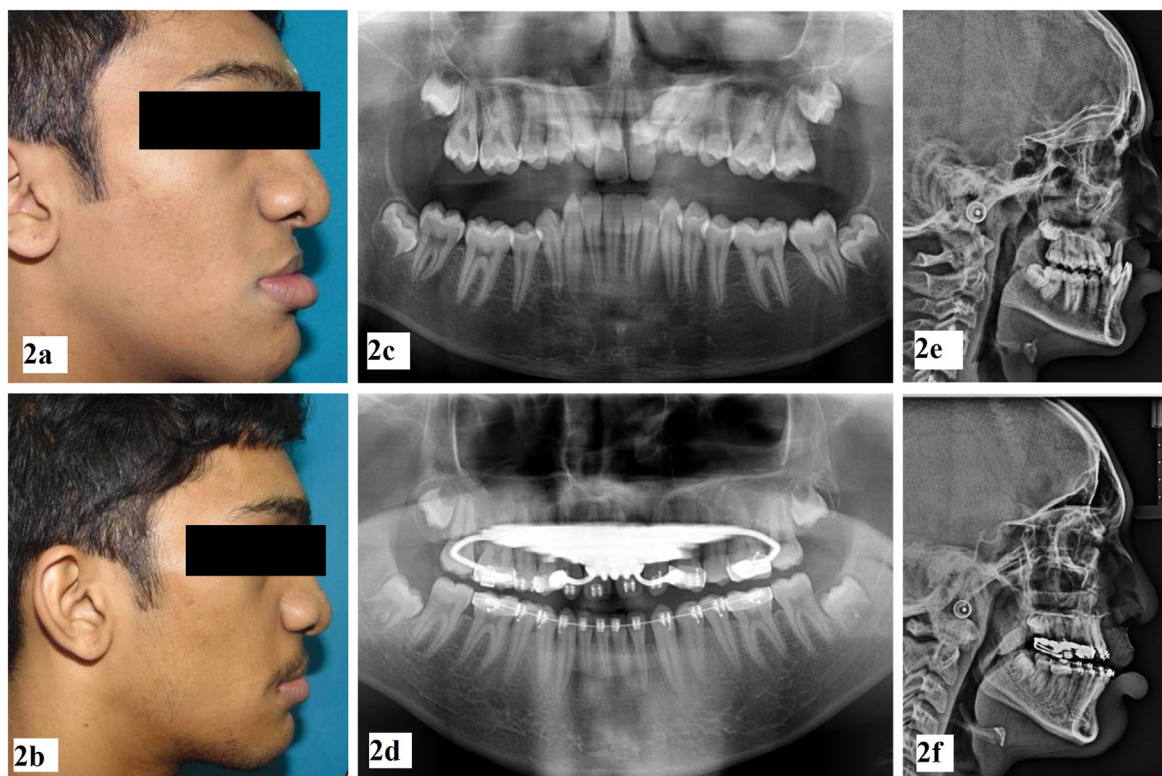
A-b) Pre and post-operative lateral facial profile; c-d) Pre and post-operative orthopantomogram of the patient; e-f) Pre and post-operative lateral cephalogram of the patient.
